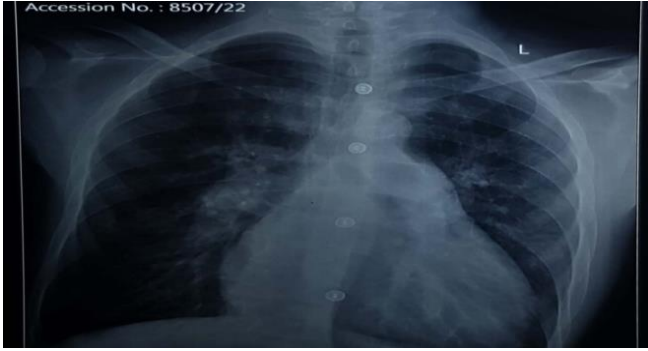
Chest X-Ray PA view revealing Cardiomegaly and prominent lung markings
